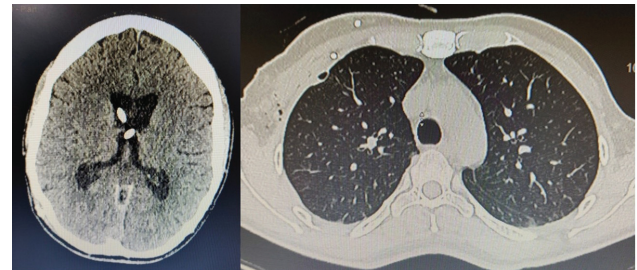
Postexternal ventricular drainage insertion computed tomographic (CT) scan showing complete resolution of pneumocephalus and postintercostal drainage insertion CT thorax showing complete resolution of pneumothorax.
